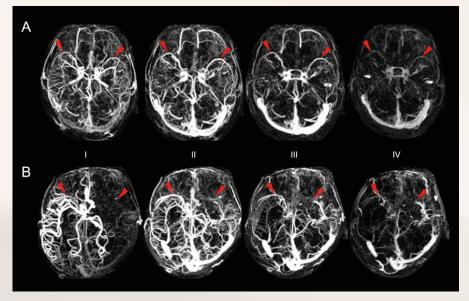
Examples of opacification of SMCV on dCTA in healthy and acute LAO patients. It's known that cerebral veins are opacified in sequence. As surface cortical veins are opacified early in the venous phase, SMCV can be well seen in this phase (I). Mid-venous phase (II and III) is always the best phase to view overall picture of cerebral veins as more down stream venous channels can be visualized. While in late venous phase (IV), the contrast within SMCV can be almost cleared out as most superficial veins are no longer visualized in this phase. Bilateral symmetrical SMCV opacification (red triangular arrow) can be seen in the healthy control subject from early to late phase (see patient A, I-IV). According to this regularity, SMCV was defined as negative (SMCV-) if no contrast filling of SMCV across the whole venous phase in the ischemic hemisphere. Otherwise, it was defined as positive (SMCV+). In patient B with acute left intracarotid artery occlusion, the ipsilateral SMCV (see the left red triangular arrow) that did not present on dCTA from early to late venous phase was marked as SMCV-. SMCV, superficial middle cerebral vein; dCTA, dynamic computed tomography angiography; LAO, large artery occlusion.
